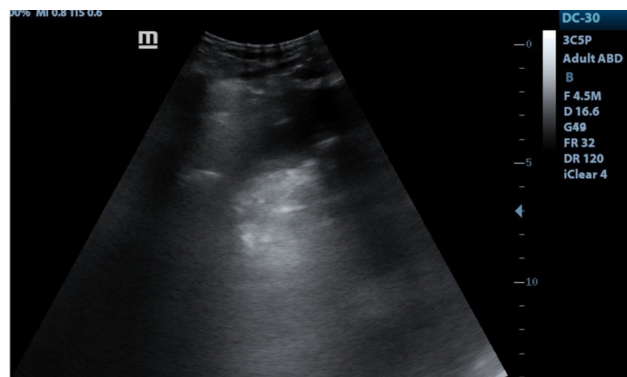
Lung ultrasound showing pulmonary consolidation.
